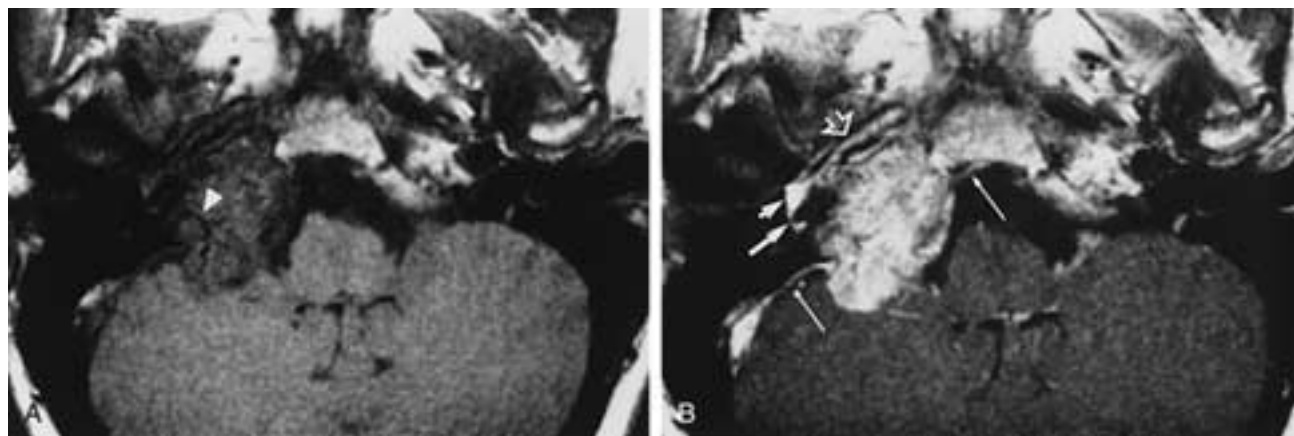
Jugular paraganglioma (glomus jugulare tumor) with posterior fossa extension. A, T1-weighted image. B, Gadolinium T1-weighted image. Note the loss of natural contrast between the tumor and the clivus marrow after Gd-DTPA administration and the importance of precontrast images to serve as a baseline. The tumor circumferentially narrows the intrapetrous carotid (*open arrow*) and extends to the protympanum (*short arrow*) to surround the cochlea (*arrow*). Note the dural tails (*long, thin arrows*) and arterial branch (*arrowheads*) supplying the tumor. Note also the intracranial extension. (From Jackler RK, Brackmann DE, eds. Neurotology. St. Louis: Mosby-Year Book, 1994.)
